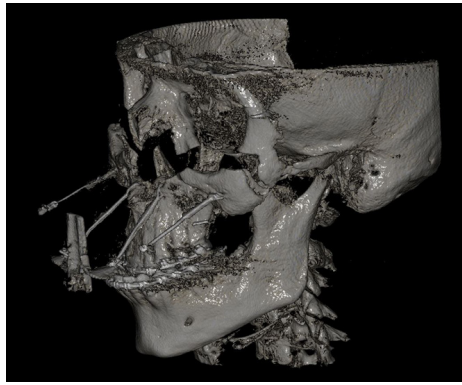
Cone beam computed tomography showing the wires anchored directly to the bone
